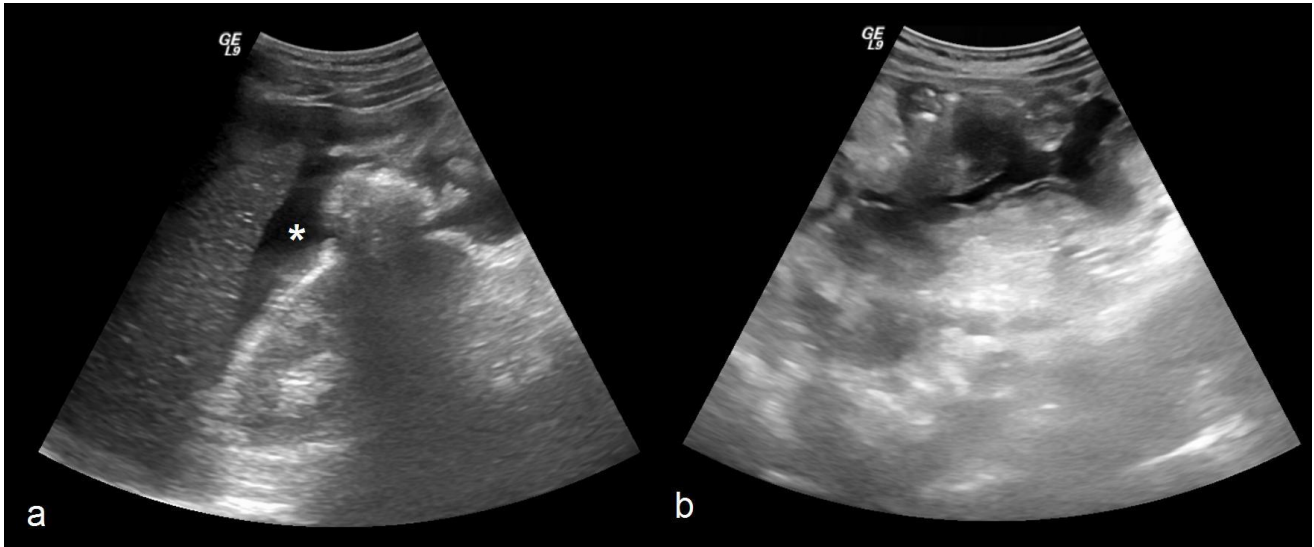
Sixty-one-year-old male with Burkitt lymphoma. Upper abdominal ultrasound using a curve probe (3-5 MHz). a) Longitudinal scan of the right hypochondrium shows peritoneal anechoic effusion in the Morison pouch (asterisk); b) Transversal scan of the epigastric region demonstrates heterogeneous nodular thickening of the anterior abdominal wall.
